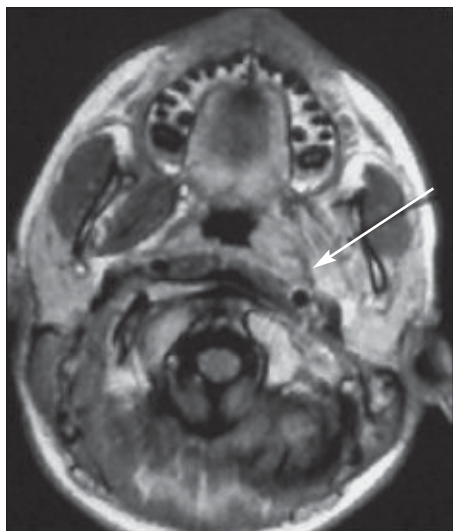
(left) MRI of the patient prior to therapy showing loss of image of the left medial pterygoid muscle (*arrow*).
